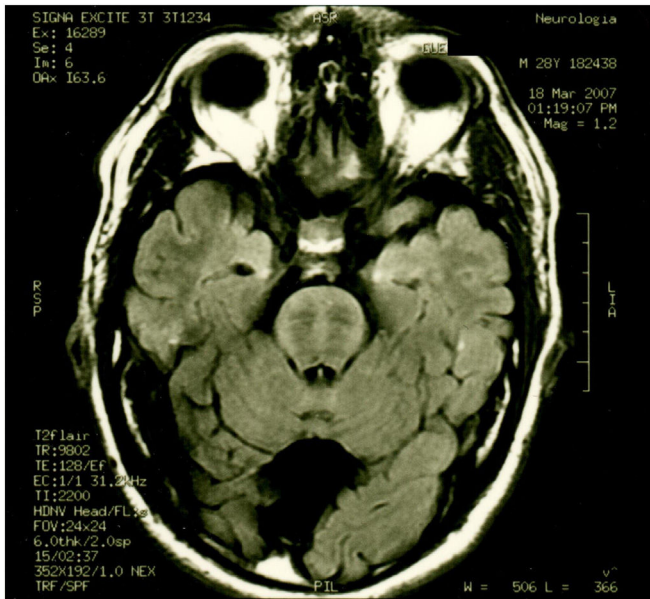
Axial FLAIR MRI. Pontine striae and a retrovermian cyst.
